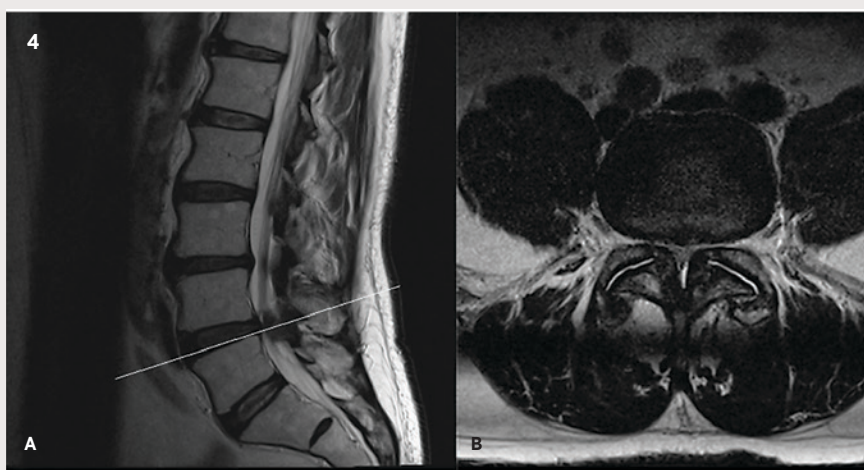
(Above, Left) T2-weighted mid-sagittal (A) and axial (B) MRI images showing severe lumbar spinal stenosis at the level of L4-L5. Figure 5. (Above, Right) The characteristics of PT and lumbar lordosis (LL) in patients with hip OA. Spinopelvic balance is shown in an individual without OA (Fig. 5A) and in an individual with OA (Fig. 5B). [3] Pelvic Tilt (PT), Lumbar Lordosis (LL). Figure 6.¹⁹ (Far Left) Sacral slope (SS), Sacroacetabular angle (SAA), Sacral inclination (SI) postural differences. Differences in low SI angle (Near Left) (1) and high SI angle (2) with high SI angle preventing anterior impingement.
